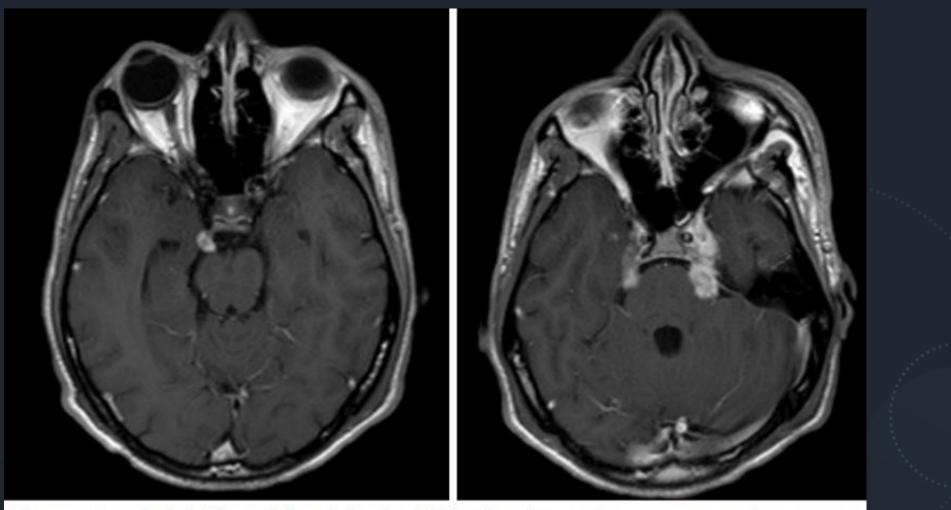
Axial T1-weighted brain MRI showing enlargement and contrast enhancement in the right oculomotor nerve and bilateral trigeminal nerves.
